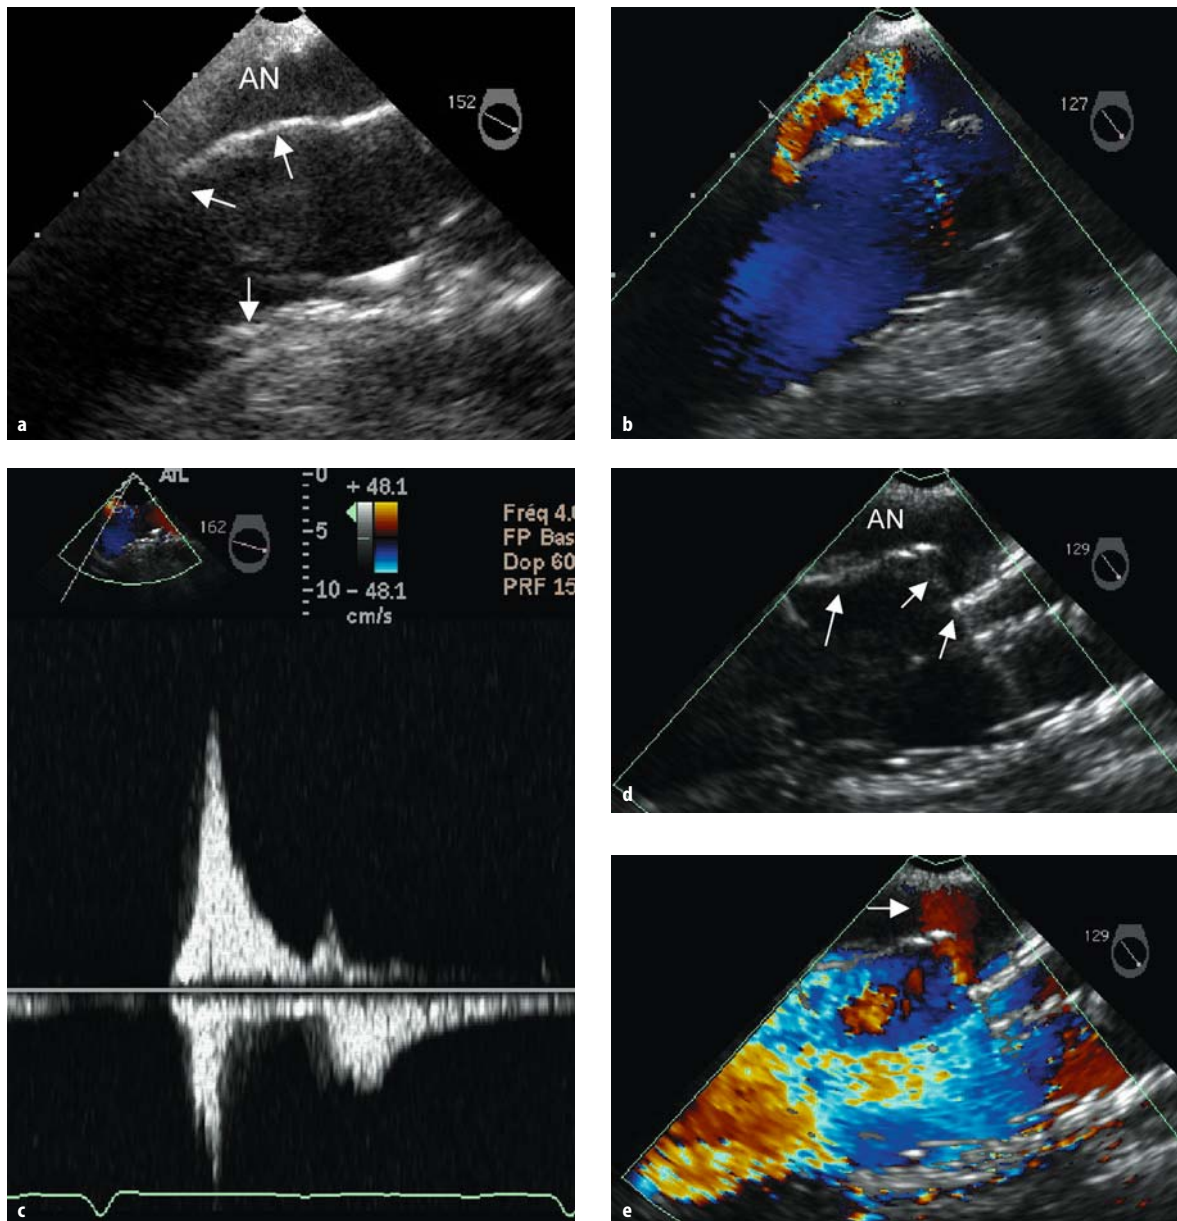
Stent leak type I: a partial contact between the aortic wall and the stent (*arrows*); b, c color Doppler and pulsed Doppler images of the leak. Stent leak type IV: d stent protrusion (*arrows*) into the aneurysm (AN); e leak (*arrow*) through the stent
